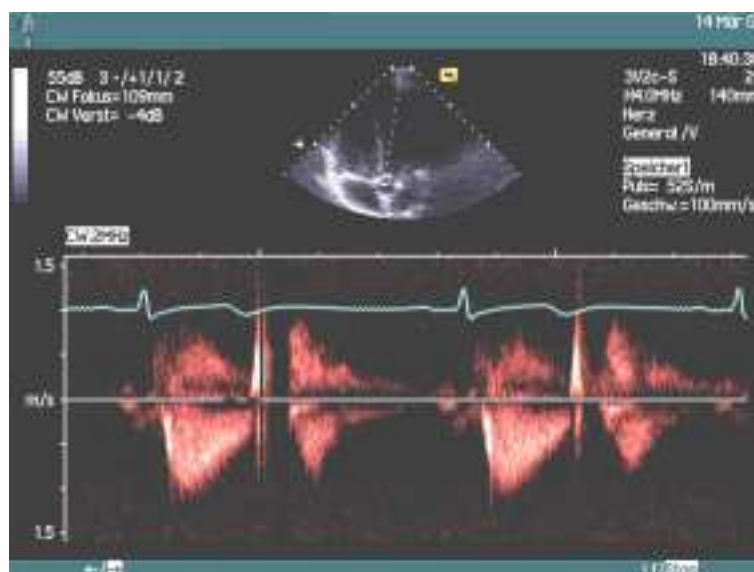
Ultrasound measurement for the flow velocity at the aortic root
